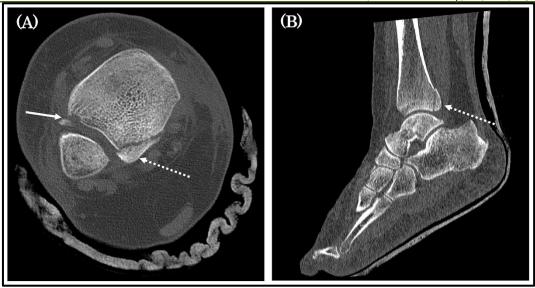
Axial (A) and coronal (B) CT images of the ankle demonstrating fractures of the posterior (dotted arrows) and anterior (solid arrow) malleoli
